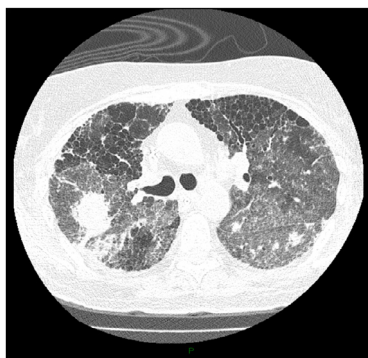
Chest CT scan showing diffuse ground glass opacities together with bilateral multiple irregular nodular opacities, peripheral cystic areas and bronchiolectasis.
